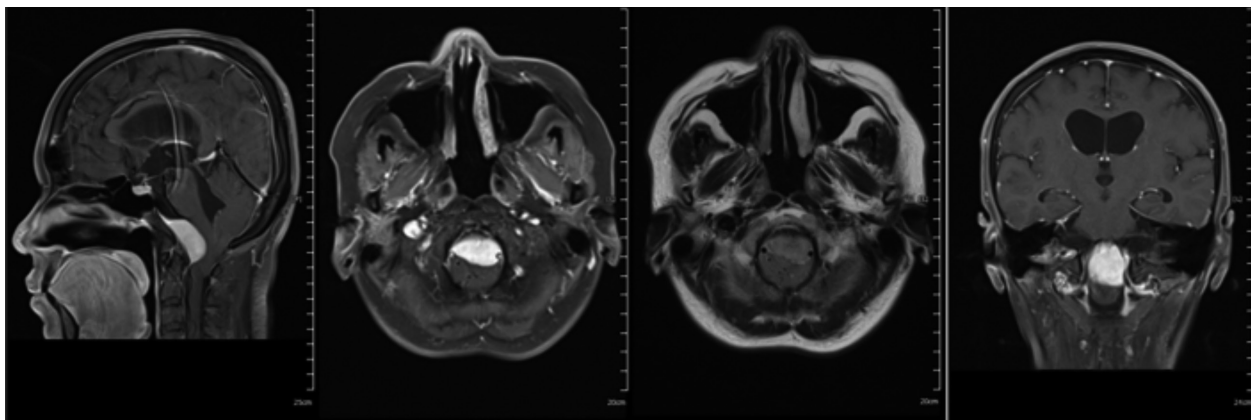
Magnetic resonance imaging (MRI) scan revealing a mass with a board dura base. This was a homogenously enhancing mass, measuring about 2.2 x 3.3 x 3.3 cm in the prepointine cistern, pre-medulla oblongata, posterior aspect of the clivus, and craniocervical junction, encasing the left vertebral artery, with a mass effect to cause canal stenosis. Foramen magnum meningioma is the most likely diagnosis.
